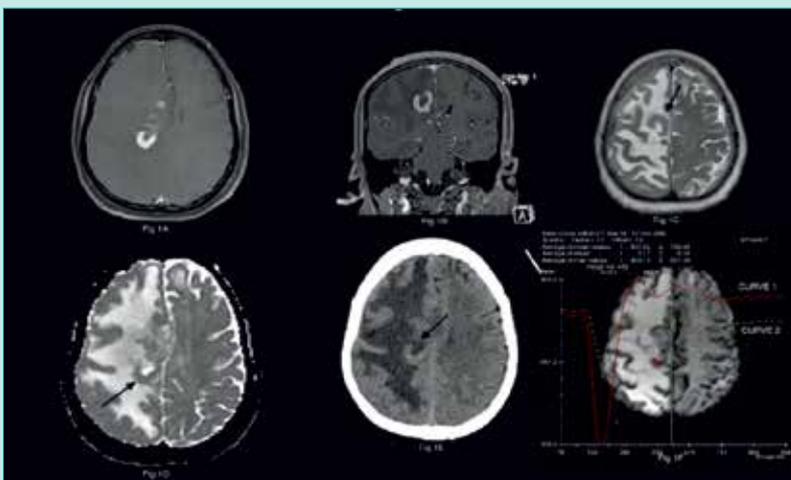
Fig 1A (Post contrast T1w fs axial) and Fig 1B (Post contrast T1w fs coronal) show open ring enhancing lesions in right frontoparietal lobe. Fig 1C (T2w axial) shows hypointense open ring lesions in right high frontal lobe. Fig 1D (ADC axial) shows diffusion restriction in the lesion. Fig 1E shows lesion to be hyperdense on plain CT head. Fig 1F shows peak signal recovery (PSR) curve obtained from the lesion (curve 1) shows increased PSR overshooting the baseline compared to normal measurement (curve 2).
